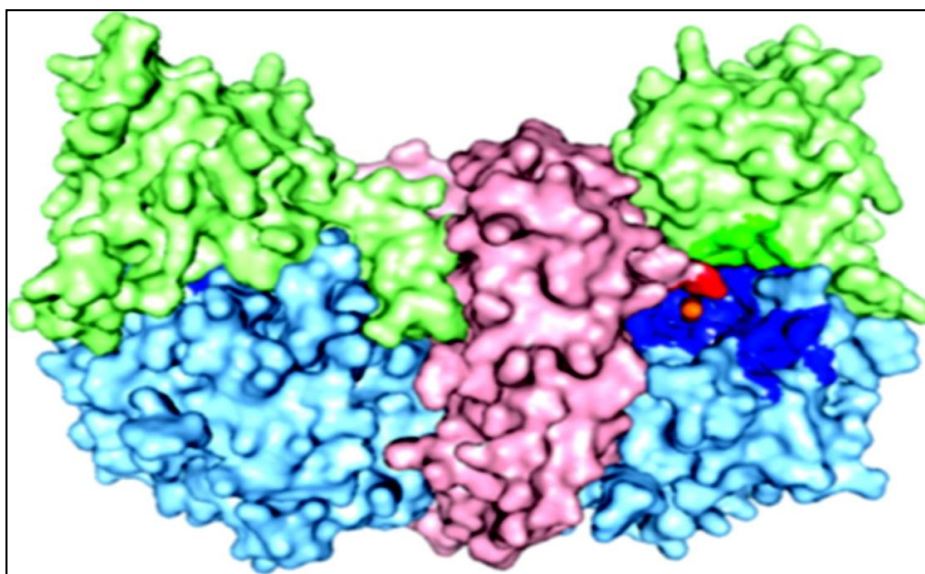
PSMA surface rendering in which the helical domain is light red, the apical domain is light green, the protease domain is light blue, and zinc ions are orange. The residues lining the substrate-binding cavity are highlighted in a darker version of the color corresponding to the domain from which the residue originates [33].
